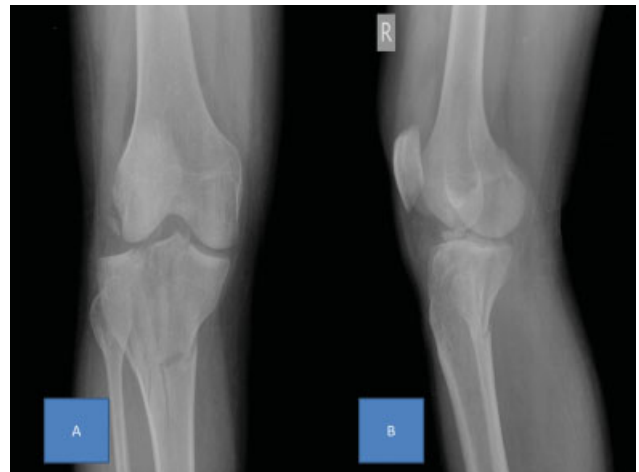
and 6B Preoperative anteroposterior and lateral radiographs of Patient 13.
